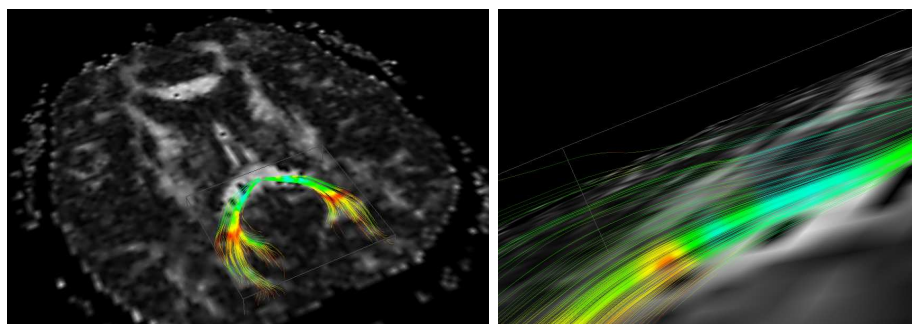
Diffusion MRI: Inferred geodesics by intrinsic integration
